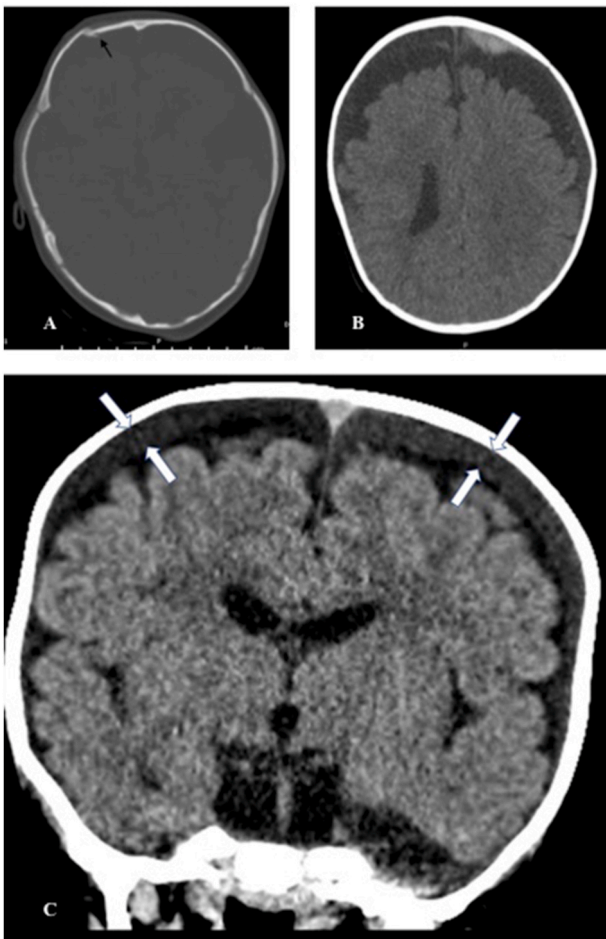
(A) Axial non-contrast enhanced CT of the head showing a depressed right frontal skull fracture (indicated by black arrow). (B) Axial non-contrast enhanced CT of the head depicting a hyperdense subdural fluid collection along the left anterior frontal convexity most consistent with an acute subdural hematoma. (C) Coronal CT image demonstrating isodense bilateral convexity subdural collections (between white arrows) and subjacent enlarged sub-arachnoid spaces.
